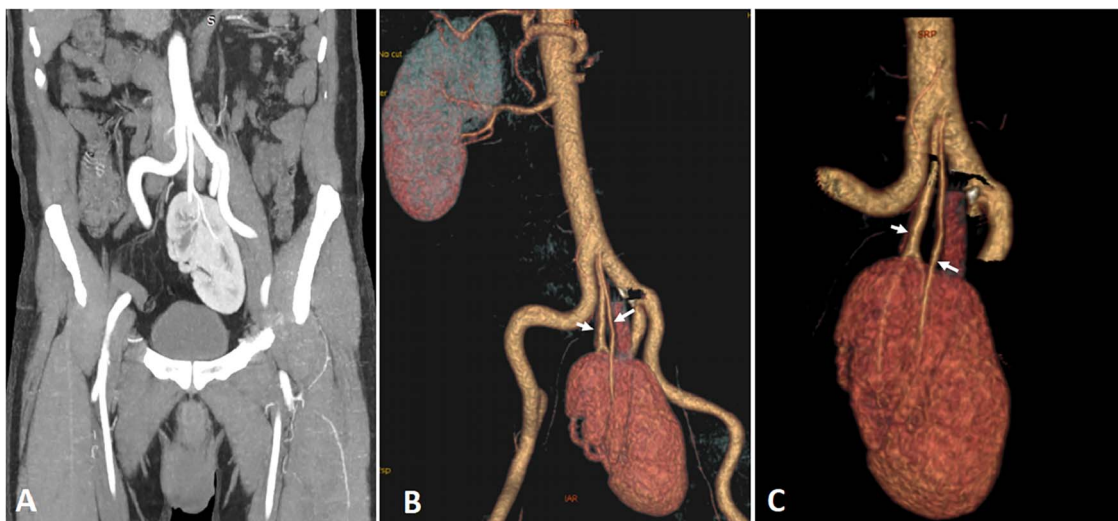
Contrast-enhanced abdominal CT scan on the coronal plane (A) and volume rendering (B, C) showing a pelvic kidney with double artery vascularization from common iliac arteries (arrows).
